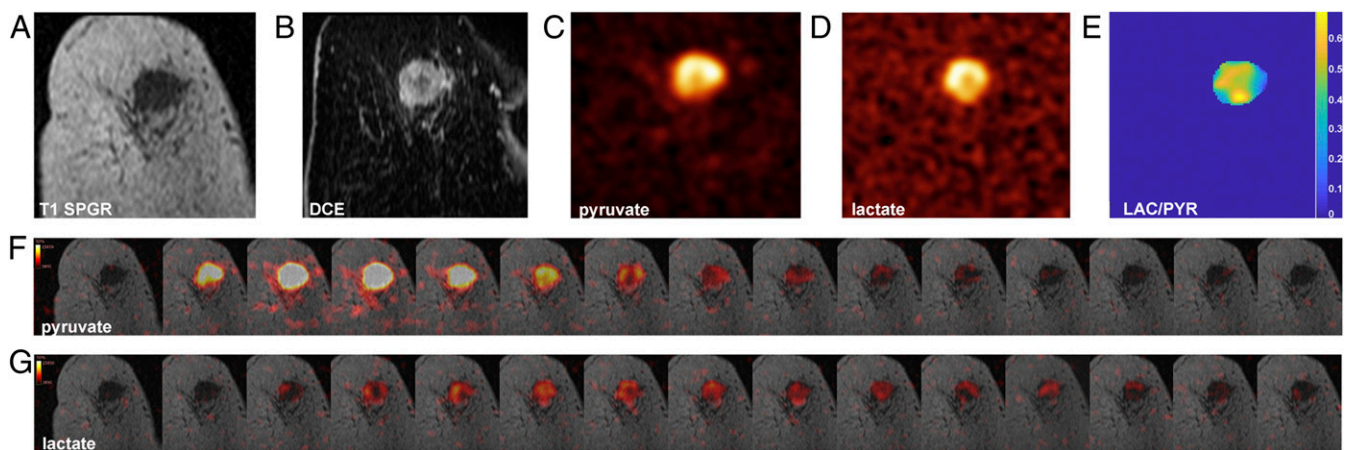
The ^{13}C -pyruvate and ^{13}C -lactate images acquired following i.v. injection of hyperpolarized [$1\text{-}^{13}\text{C}$]pyruvate in a patient with TNBC. (A) Coronal T1 3D spoiled gradient echo (SPGR) image. (B) Coronal reformatted DCE image at peak enhancement after i.v. injection of a gadolinium-based contrast agent. (C) Summed hyperpolarized ^{13}C -pyruvate and (D) summed hyperpolarized ^{13}C -lactate images: area of low ^{13}C -pyruvate and ^{13}C -lactate signals in the center of the tumor, likely corresponding to an area with low enhancement on DCE. (E) LAC/PYR map showing intratumoral heterogeneity (background removed by thresholding). The dominant intratumoral heterogeneity was concordant between the DCE-MRI and HP ^{13}C MRI images and represents decreased delivery of both the gadolinium-based contrast agent and ^{13}C -pyruvate to the center of the tumor. (F and G) Dynamic hyperpolarized ^{13}C -pyruvate and ^{13}C -lactate images acquired over 15 time points after i.v. injection of hyperpolarized [$1\text{-}^{13}\text{C}$]pyruvate (delay = 12 s; temporal resolution = 4 s).
